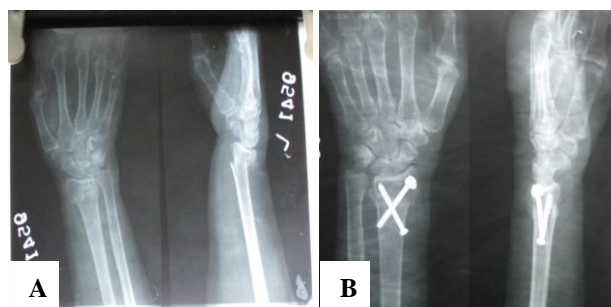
A) Pre-operative X-ray before CC screws fixation; B) Post-operative X-ray after CC screws fixation.
